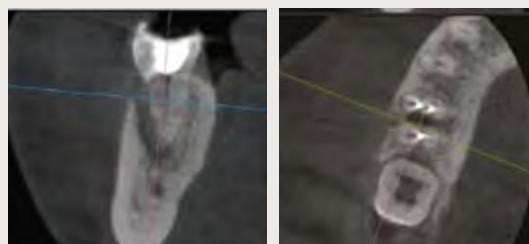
Cone beam computed tomography (CBCT) of Tooth #46 before periodontal surgery. (a) Sagittal view, (b) coronal
